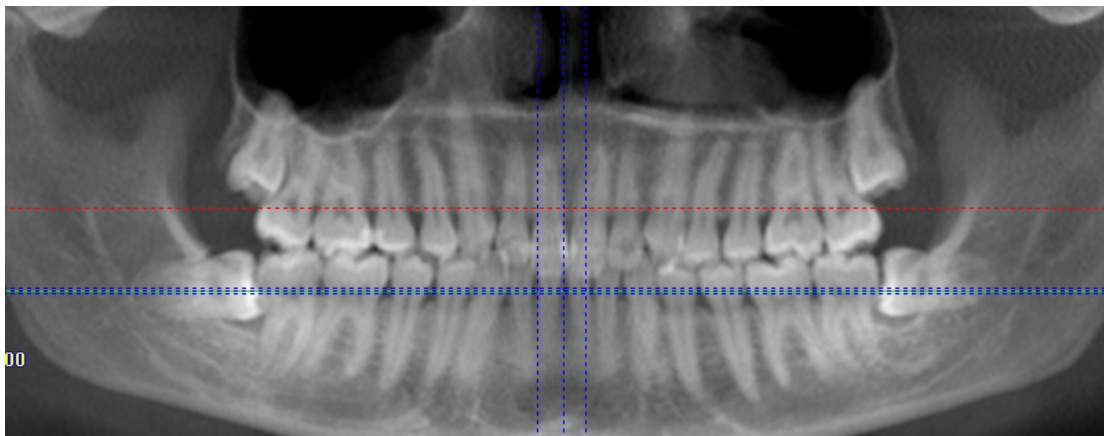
X-ray showing the development of wisdom teeth on a 12 year-old patient
